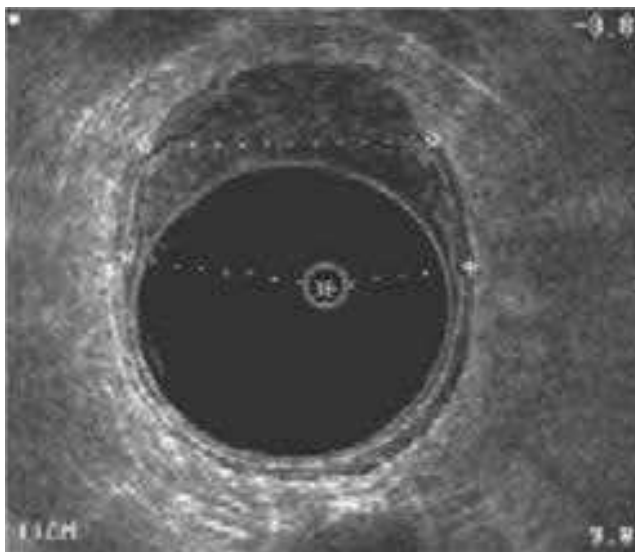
Endorectal ultrasonography showing a T3 rectal carcinoma. The dotted line is being used to measure the diameter of the lesion. (Used with permission of Charles O. Finne III, MD, Minneapolis, MN.)
